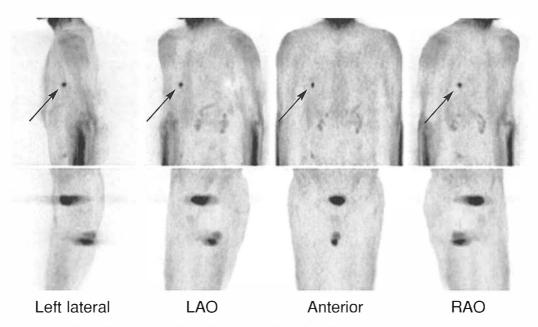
Maximum intensity projections of a patient with suspected relapse of osteosarcoma of the right tibia. Note focal accumulations of <sup>18</sup>F-FDG in both lobes of the lung without any evidence of local recurrence. This patient was staged as IVB. The patient underwent chemotherapy.
